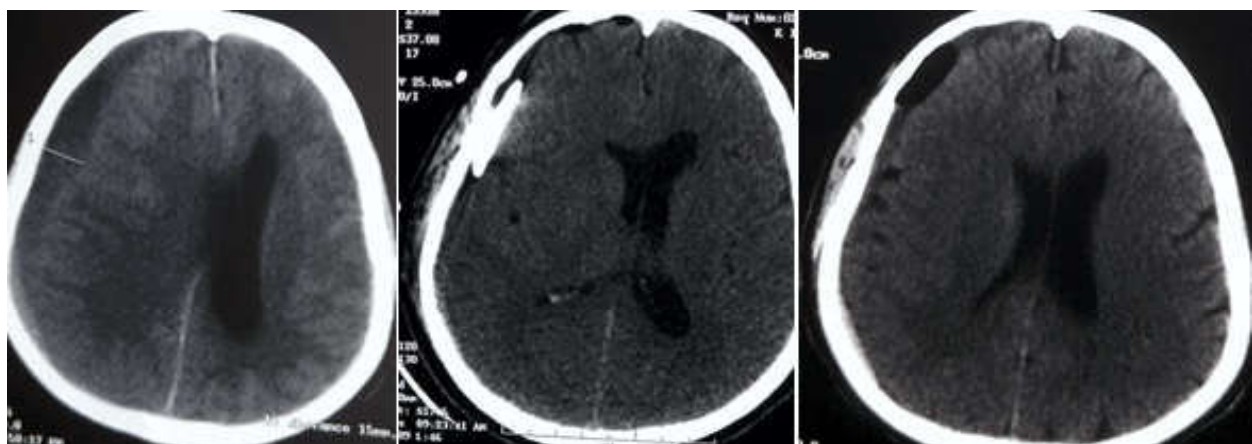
Chronic subdural haematoma treated by twist drill craniostomy, Computed Tomography scan: pre-operative, 6 hours post-operative and 48 hours post-operatively
